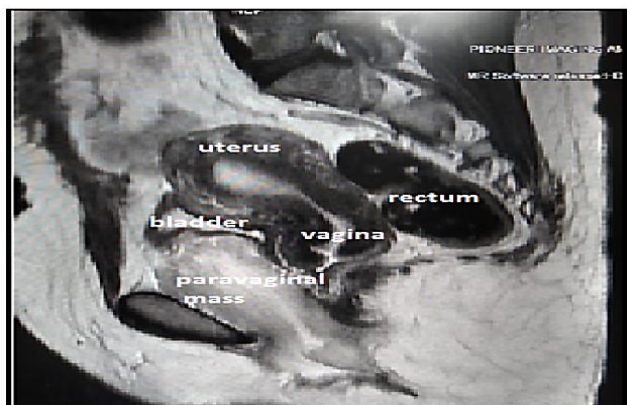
MRI (Sagittal section) showing 4.5*5.7*8.7 cm para-vaginal mass in the left peri-vesical region
